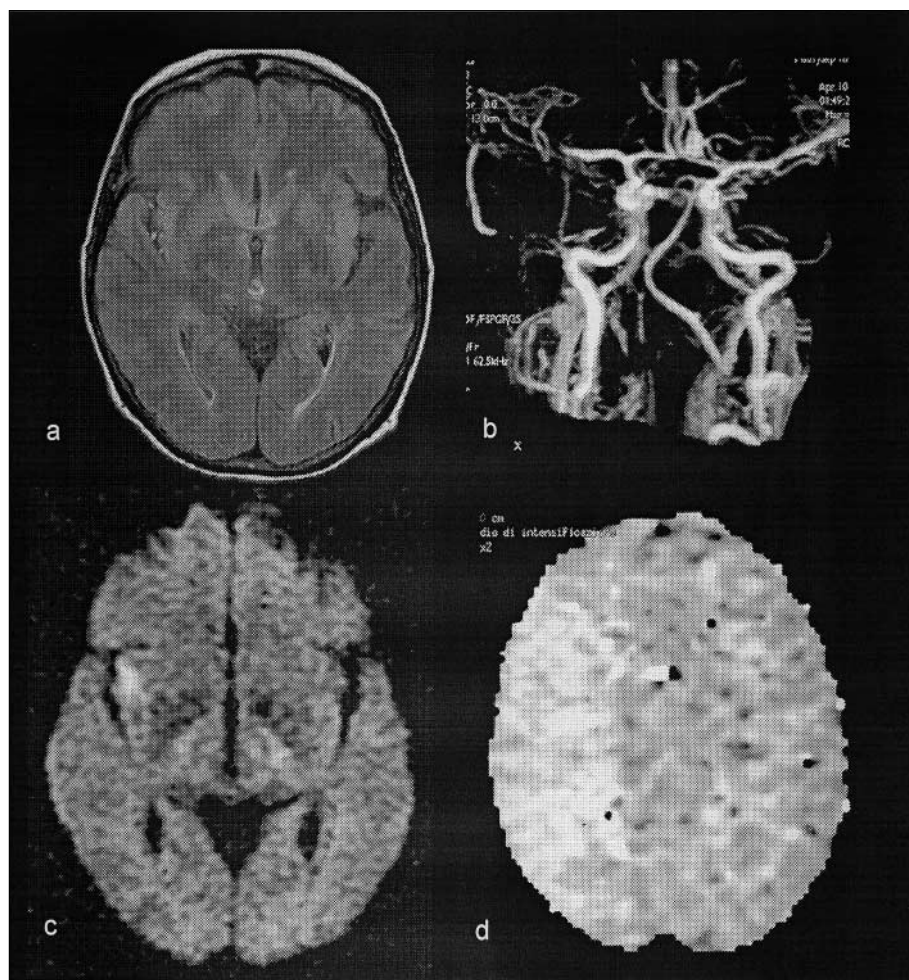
MR examination 5 hours after symptoms onset: (a) FLAIR images were normal; (b) MR angiography revealed a severe stenosis in the M2 portion of MCA; (c) DWI showed acute subinsular ischaemic lesion; and (d) PWI showed a whole right MCA territory hypoperfusion
